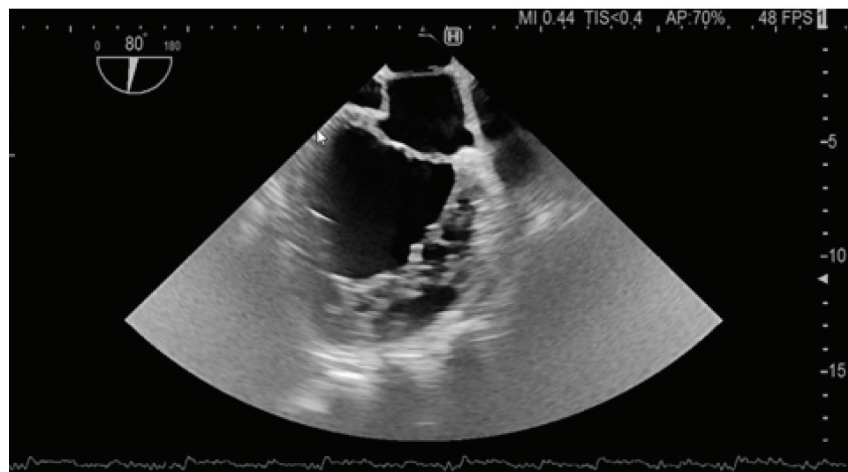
Left ventricular hypertrabeculation on transesophageal echocardiography.
